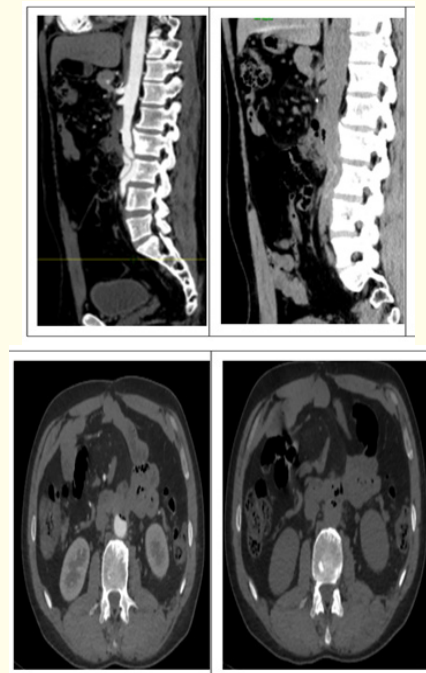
CT images showing periprosthesis aero-liquid effusions with an image suggesting an intra-duodenal foreign body.
